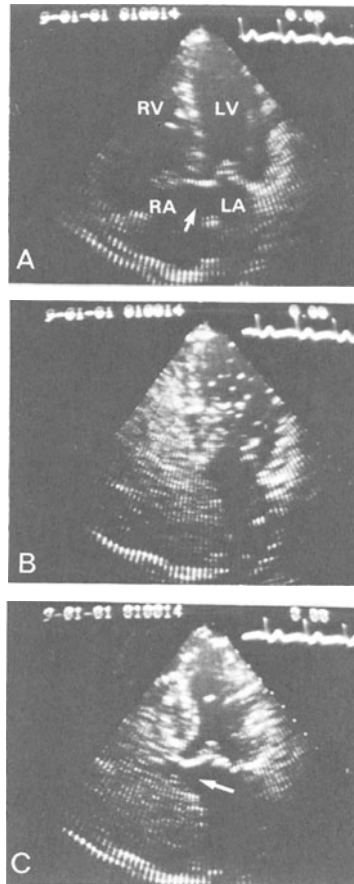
Apical four chamber views obtained from a patient with an atrial septal defect of the primum type. The defect is indicated by the arrow on panel A. Panel B shows opacification of the right-sided heart after peripheral venous injection of 5 ml of dextrose 5% in water. Echo contrast is seen in the left ventricle indicating right-to-left shunting. The negative contrast effect proving the atrial septal defect is seen on panel C (arrow) when noncontrast blood flows from the left atrium into the right atrium. A bidirectional shunt is demonstrated. AP: apex; BA: basal; L: left; R: right; LA and RA: right and left atrium; LV and RV: left and right ventricle. (From Roelandt J et al: Contrast echocardiography: clinical applications. *Verh Dtsch Ges Herz u Kreislaufforschg* 47: 185-192, 1981)
